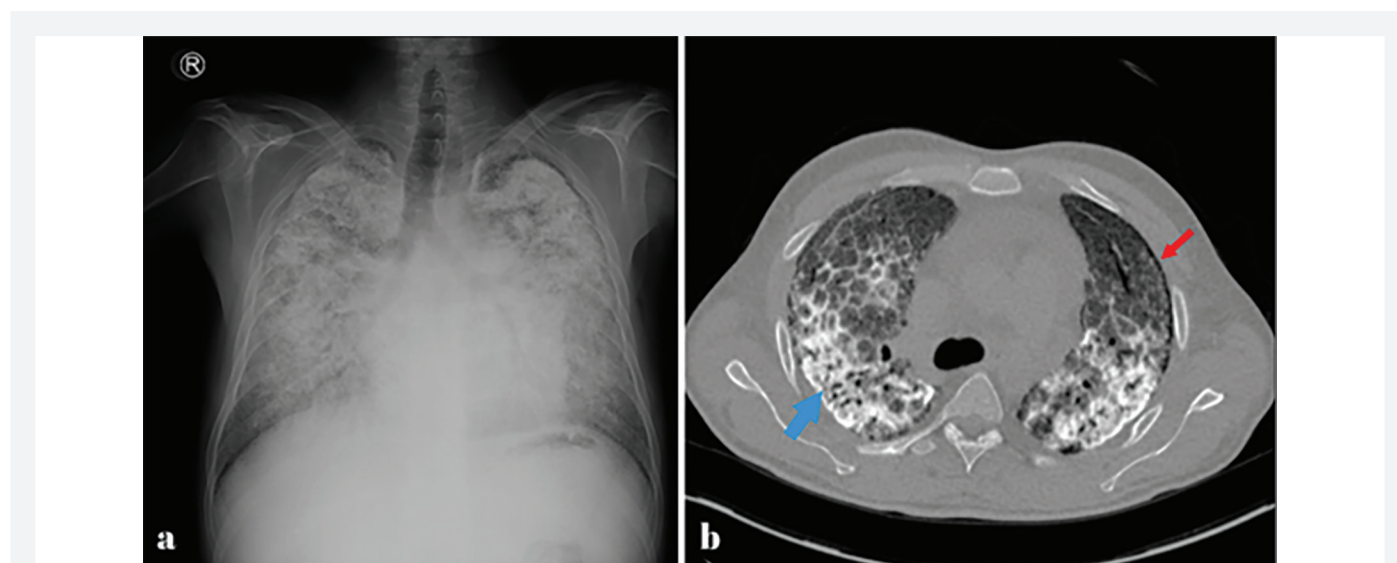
Radiological findings in pulmonary alveolar microlithiasis. (a) Posteroanterior chest radiograph showing diffuse sand like micronodular calcifications. (b) Axial thoracic CT image revealing dense alveolar microliths (blue arrow), air space obliteration, and subpleural cystic changes (red arrow), predominantly in the inferoposterior regions
